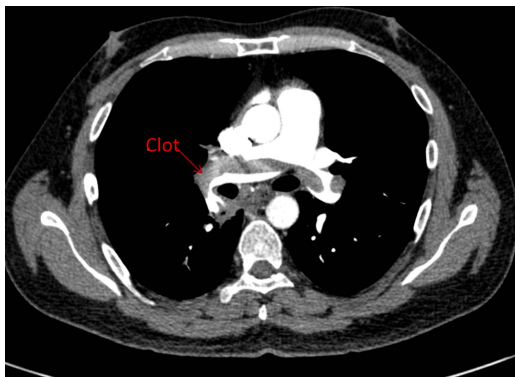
CT pulmonary angiogram revealing the features of acute pulmonary embolism.
